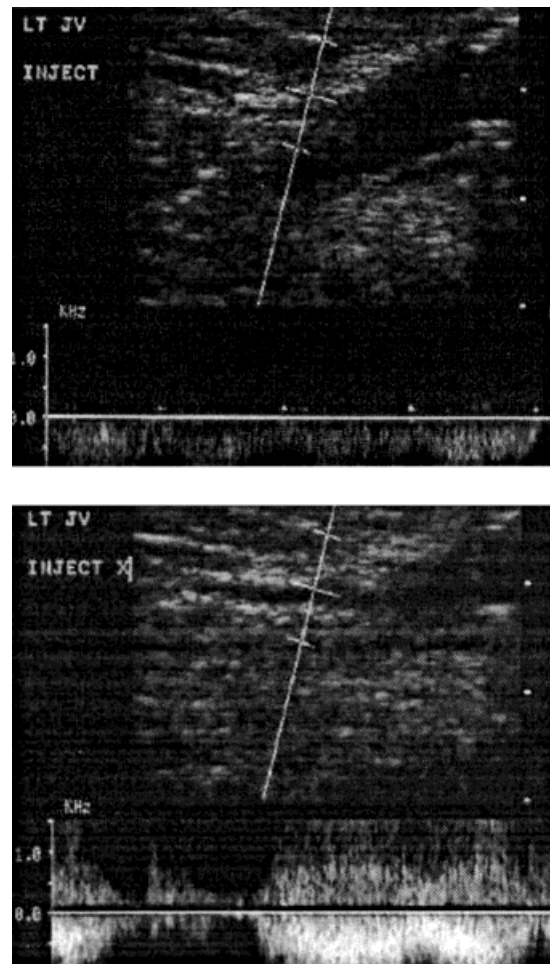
Spectral Doppler ultrasound of the internal jugular vein shows a typical venous pattern pre (top) and post (bottom) microbubbles with the typical increase in signal upon arrival of the bolus.
